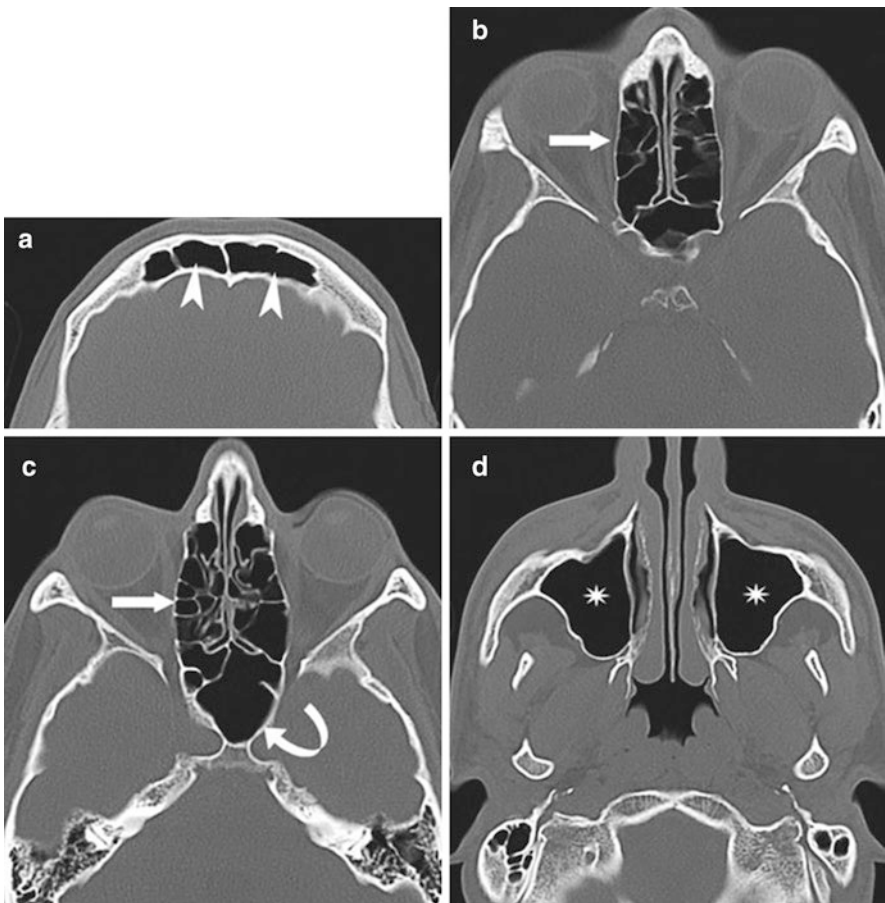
Paranasal cavities CT, axial scan, with high-spatial-frequency (bone) reconstruction algorithm. (a) Frontal sinuses (*arrowhead*). (b) Ethmoid cells (*arrow*). (c) Ethmoid cells (*arrow*) and sphenoid sinus (*curved arrow*), (d) Maxillary sinus (*asterisks*)
